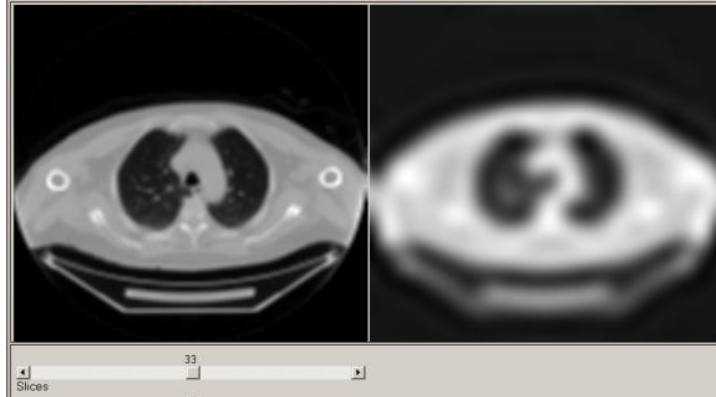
Original CT slice and its corresponding third resolution level derived from one analysis/synthesis filter bank based on the 2D Frazier-Javerth transform. The low resolution image is used to segment the body by defining a threshold.
